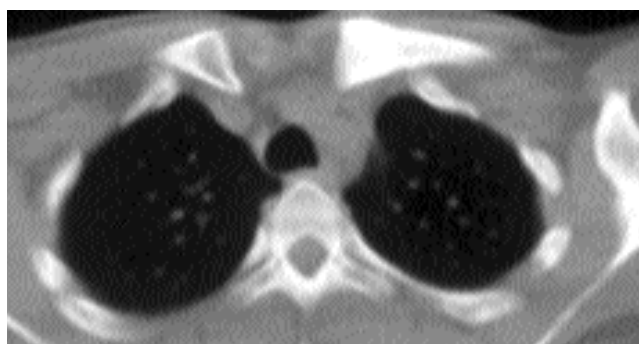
Computed tomography scanning of the clavicles demonstrated sclerosis of the marrow space of the medial end of the left clavicle.
